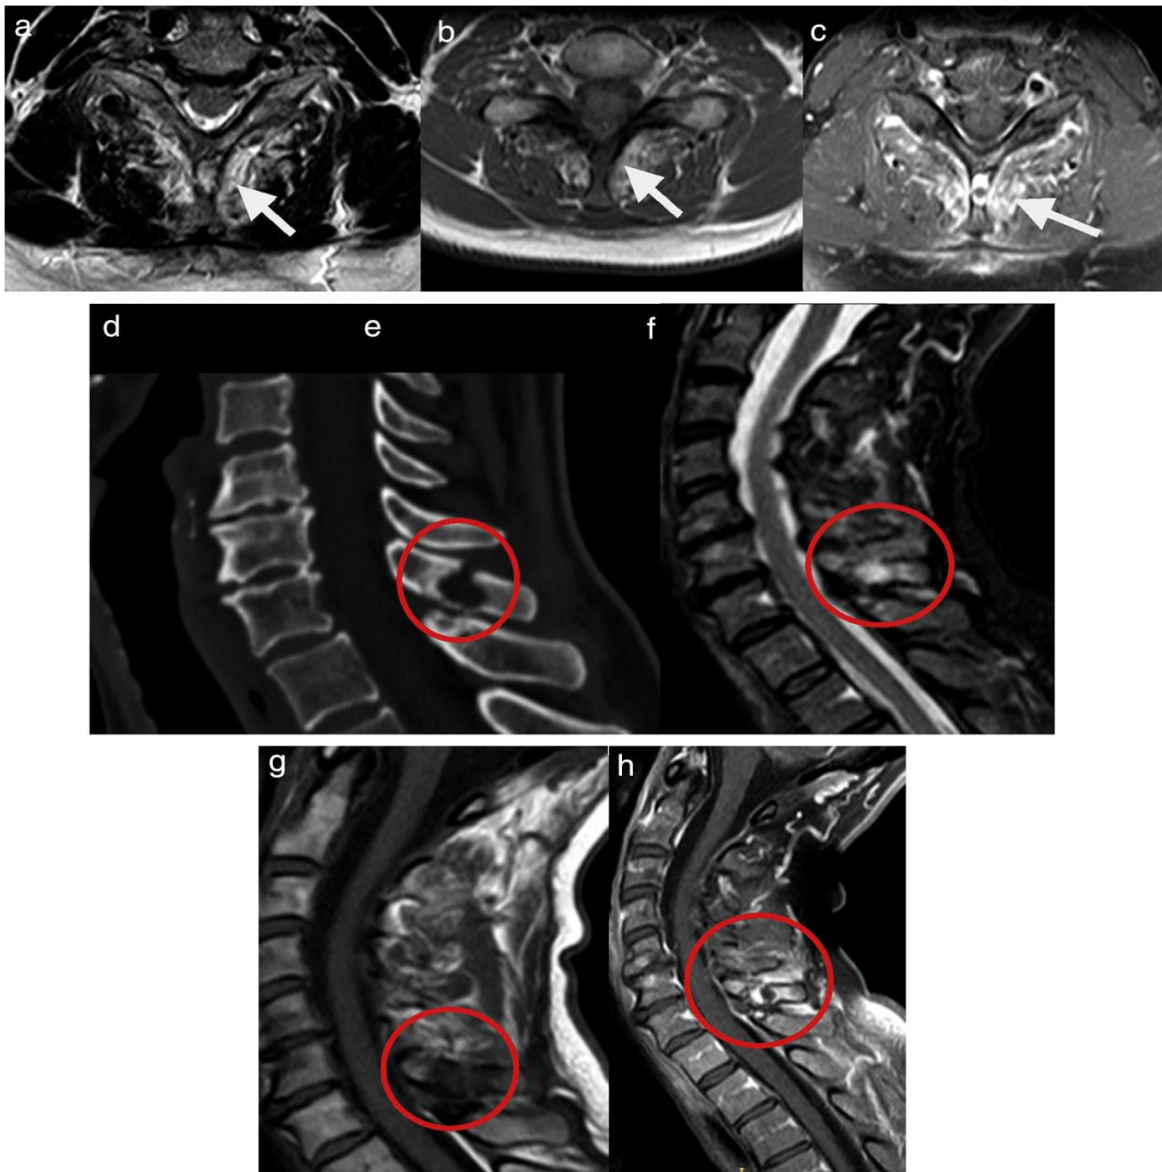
Axial and sagittal MRI and CT images, showing signs of interspinous and supraspinatus ligament enthesitis, marked by red circles in sagittal slices and arrows in axial slices. Note the marked enhancement with the use of gadolinium intravenous (c and g) of structures adjacent to a prominent rounded bone erosion focus in the spinous process of C7.
